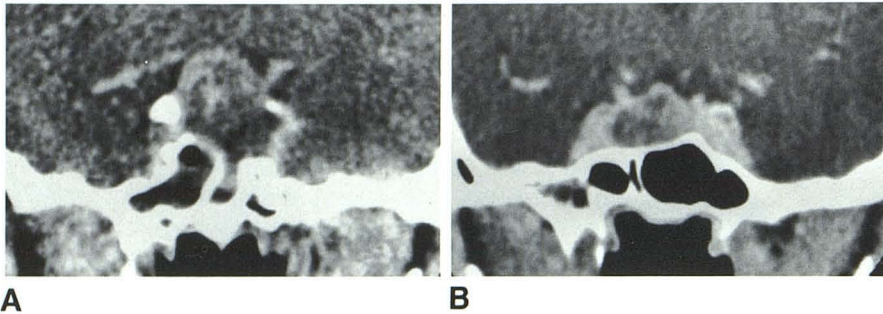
Macroadenomas with (A) and without (B) foci of old hemorrhage and infarct were radiographically similar.
